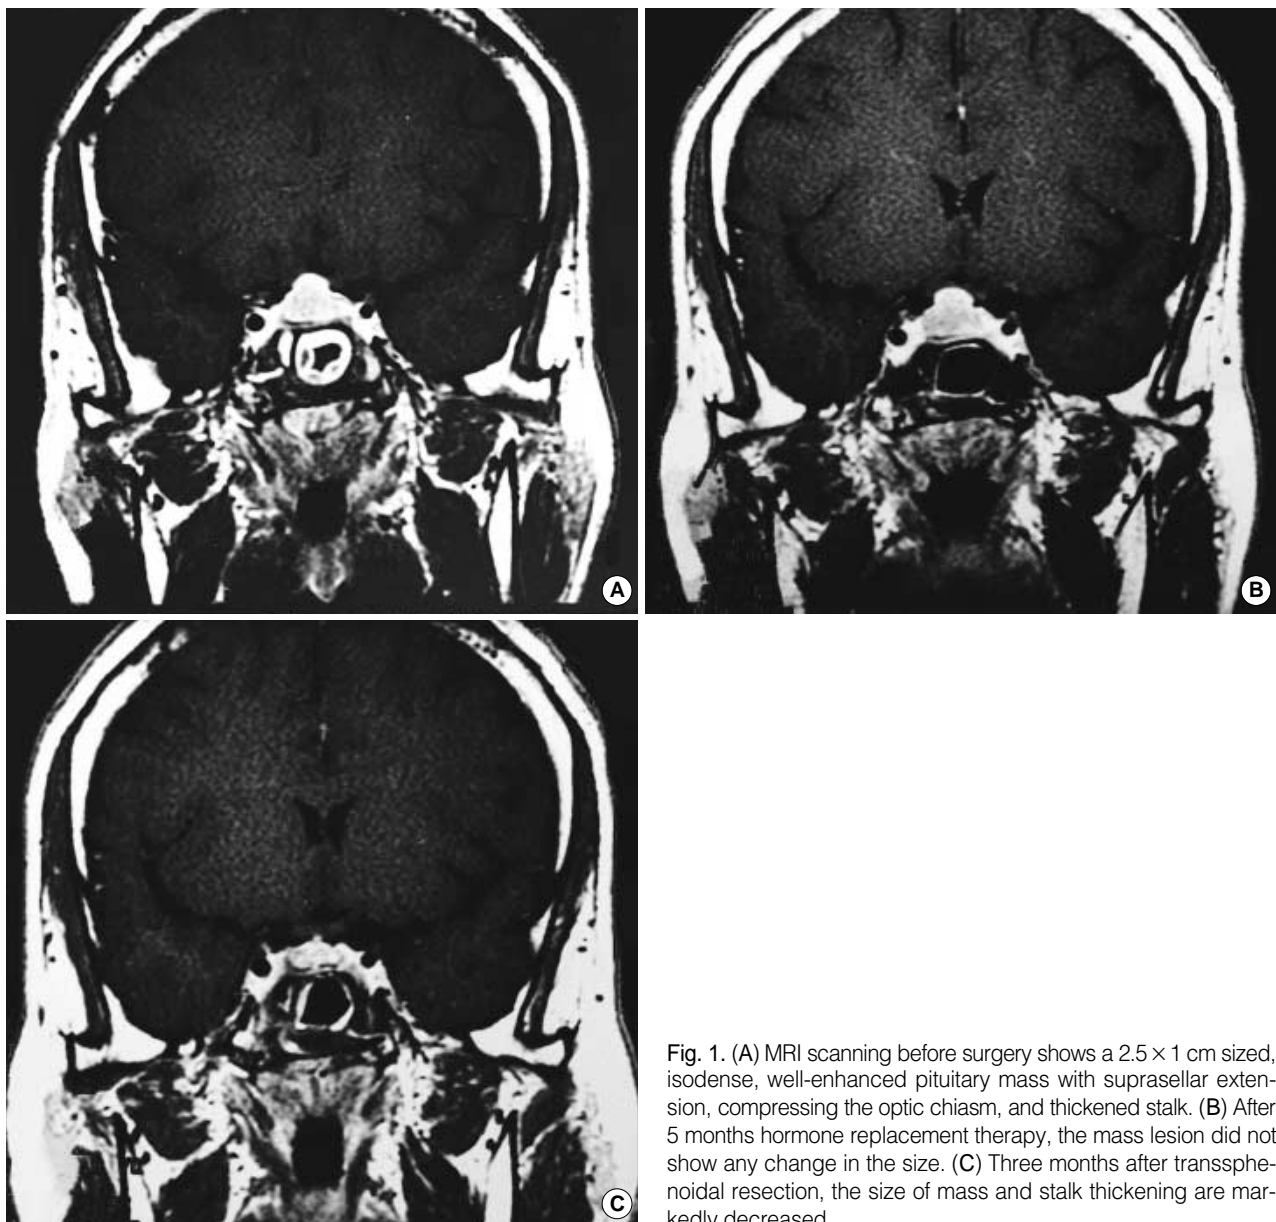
(A) MRI scanning before surgery shows a 2.5×1 cm sized, isodense, well-enhanced pituitary mass with suprasellar extension, compressing the optic chiasm, and thickened stalk. (B) After 5 months hormone replacement therapy, the mass lesion did not show any change in the size. (C) Three months after transsphenoidal resection, the size of mass and stalk thickening are markedly decreased.
